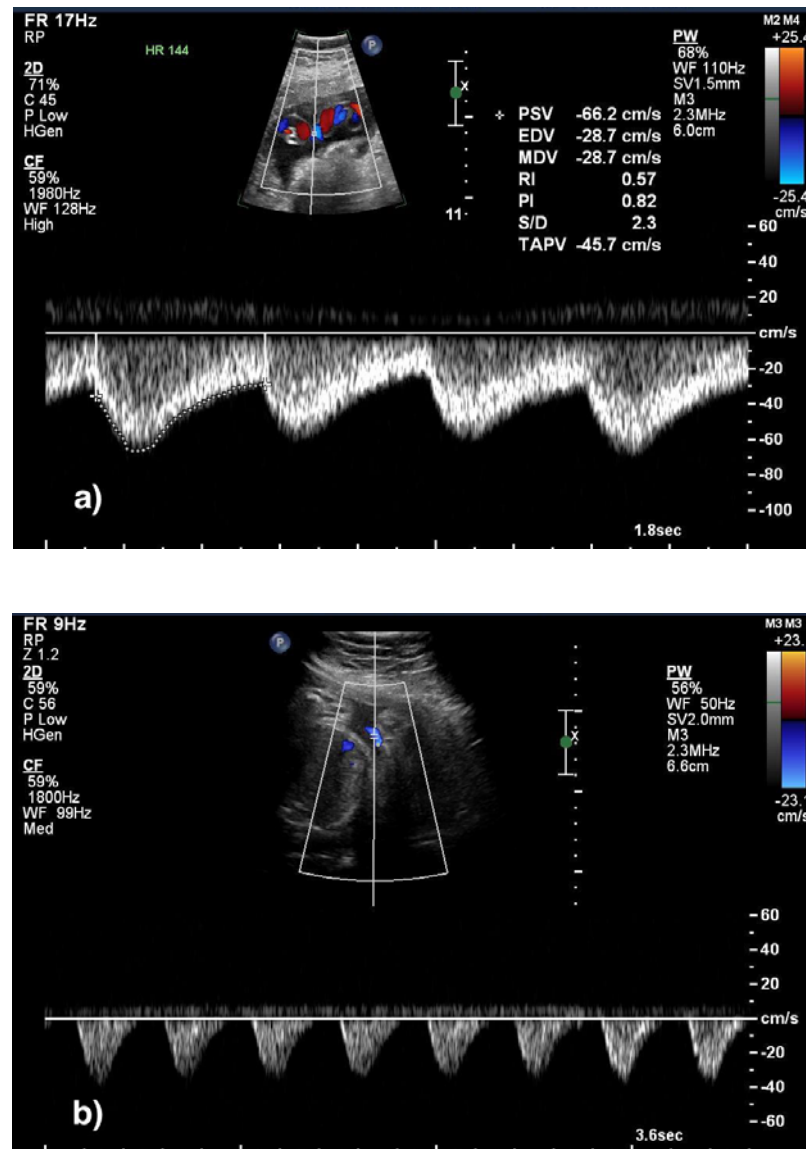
Example of normal and abnormal umbilical artery doppler. a) Umbilical artery doppler in a 37-weeks normal foetus with continuous flow throughout a cardiac cycle. b) Umbilical artery doppler in a 34-weeks IUGR foetus with absent end-diastolic flow.
